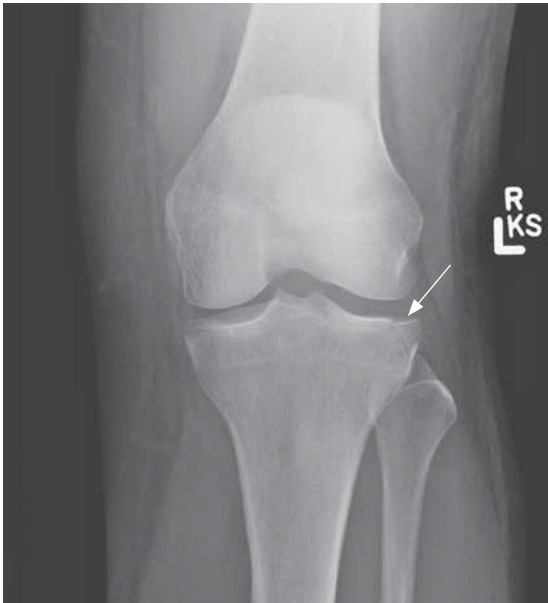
X-ray of a tibial plateau fracture
